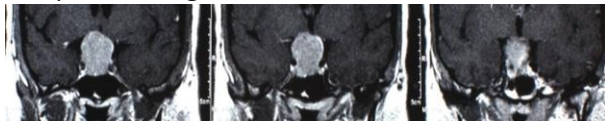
Case 4, Coronal MRI with contrast showing a 2X2.2X2.7 cm lesion.
